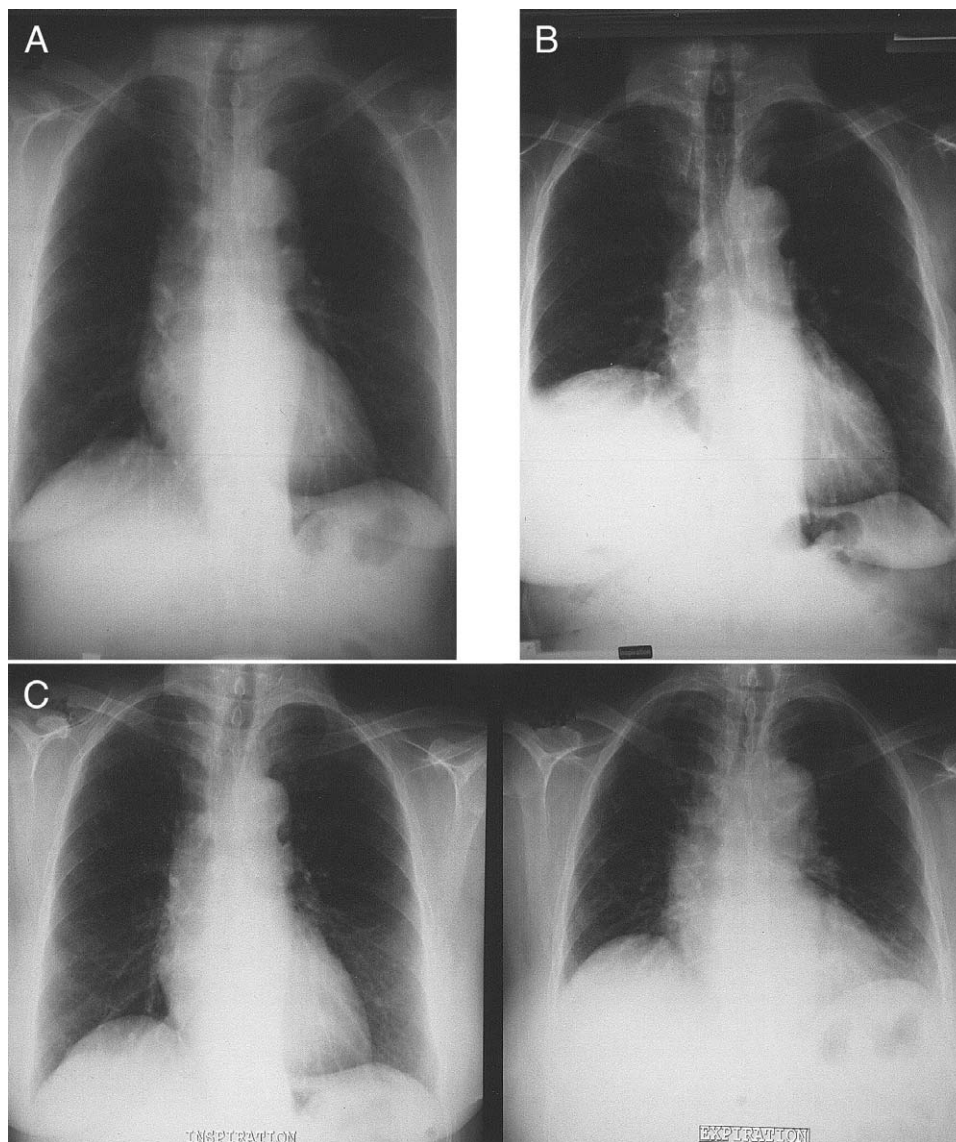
Chest X-ray during inspiration before ablation (A), just after ablation with right phrenic nerve injury (B), and one year after ablation in inspiration (C, left) and expiration (C, right).
